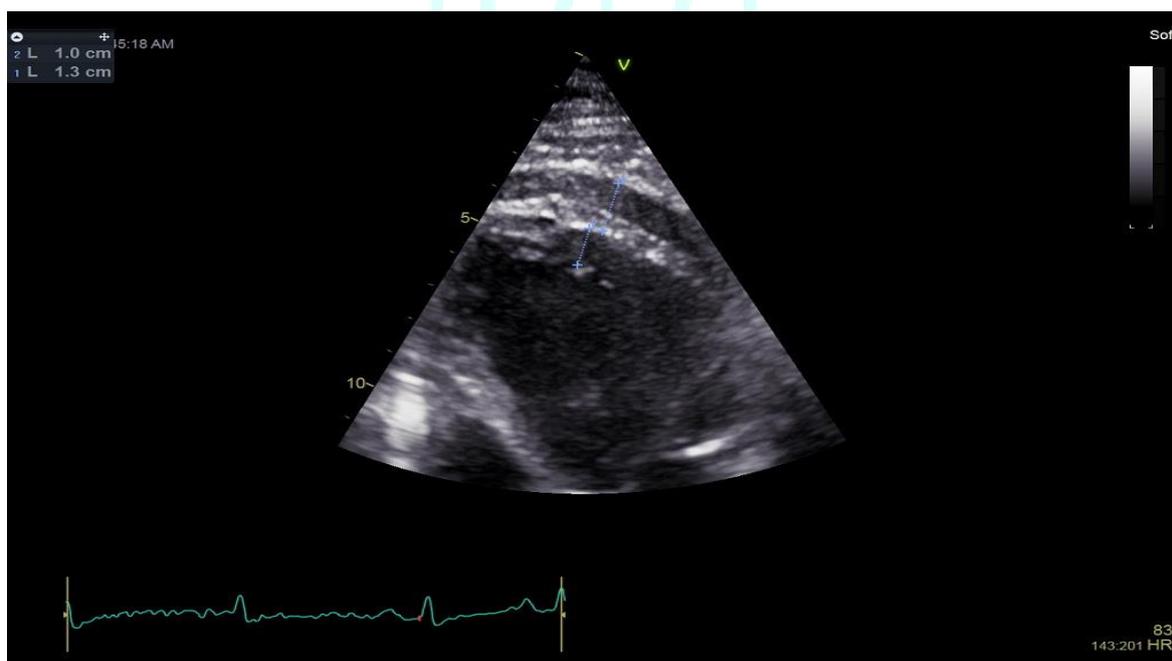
Transthoracic echocardiogram showing the thickened pericardium (13 mm) while normal is < 3 mm.
